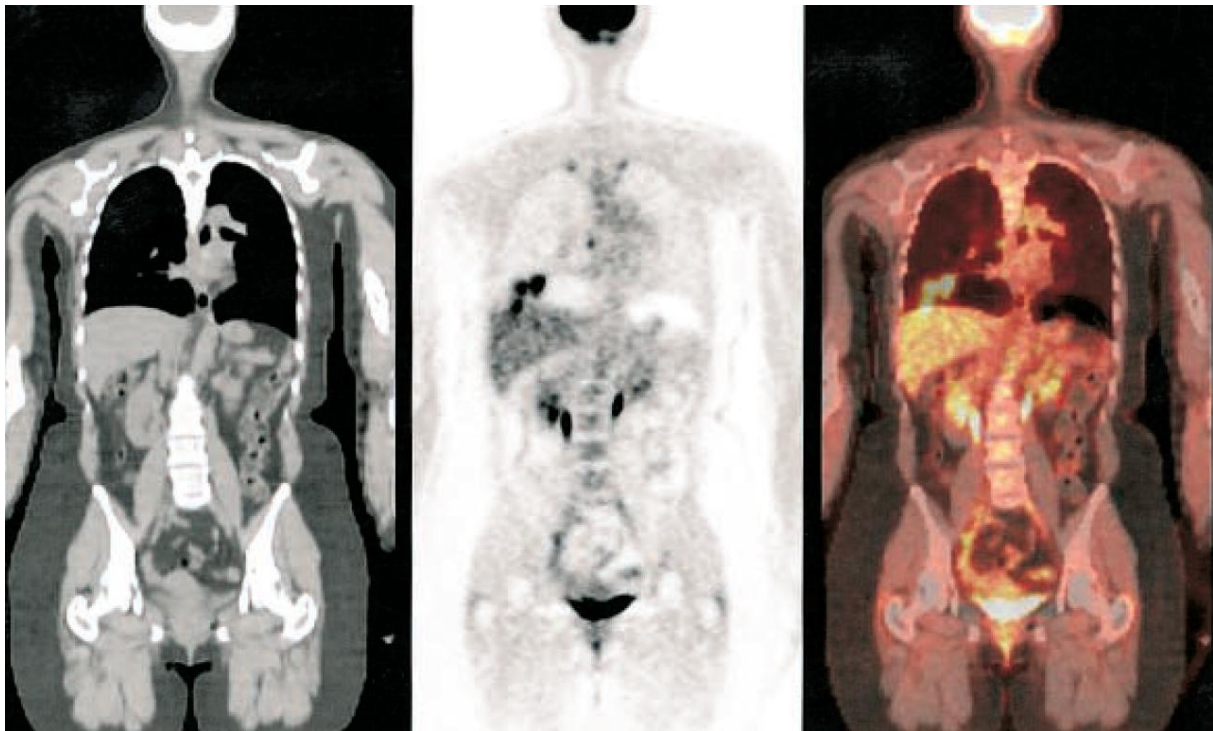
Coronal CT (left), PET (middle) and PET/CT (right) images of a 39 year old woman with breast cancer and CT-proven liver lesions but no lung lesion. Lesions are mislocalized to right lung base on fused PET/CT. Image reprinted and adapted by permission of the Society of Nuclear Medicine from [223].
